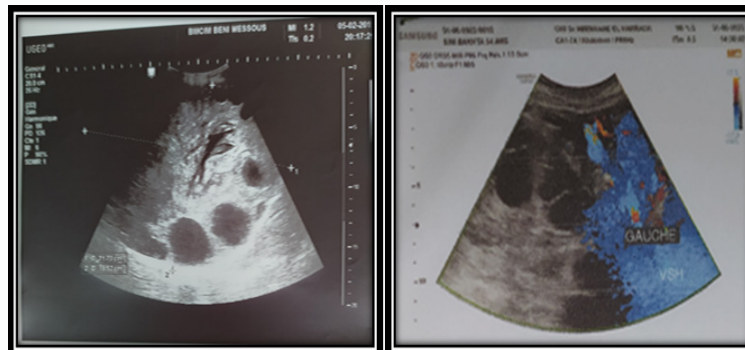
Hepatic Doppler ultrasound showing venous dilatation.
